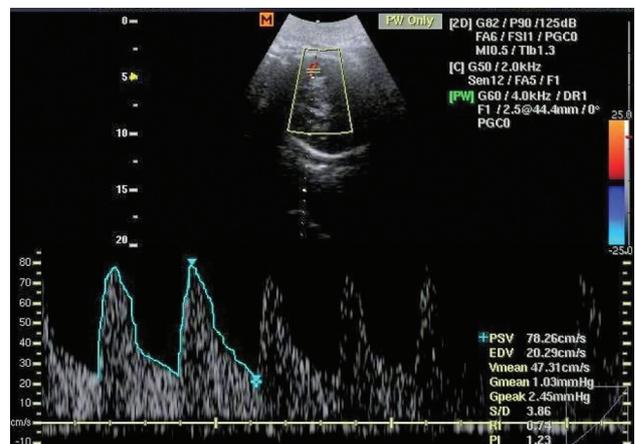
Middle cerebral artery Doppler for healthy pregnant women.
